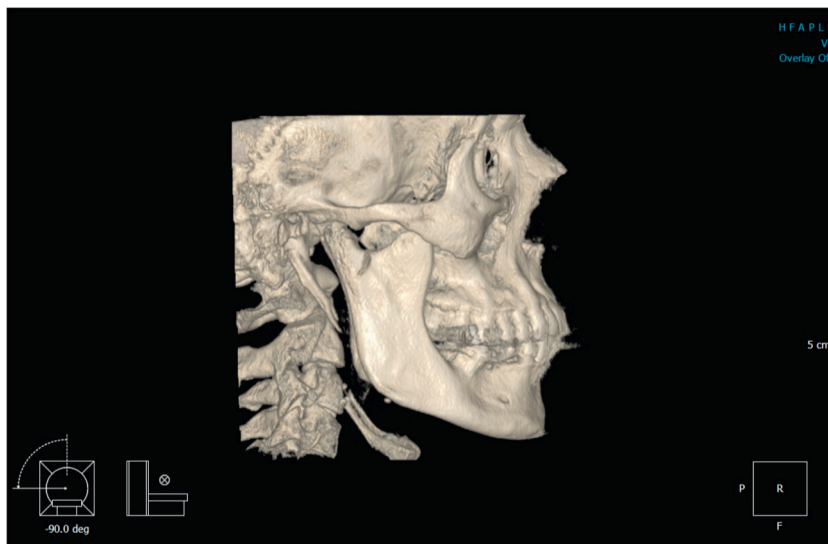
CBCT 3D images show that no evidence of tumor recurrence.
